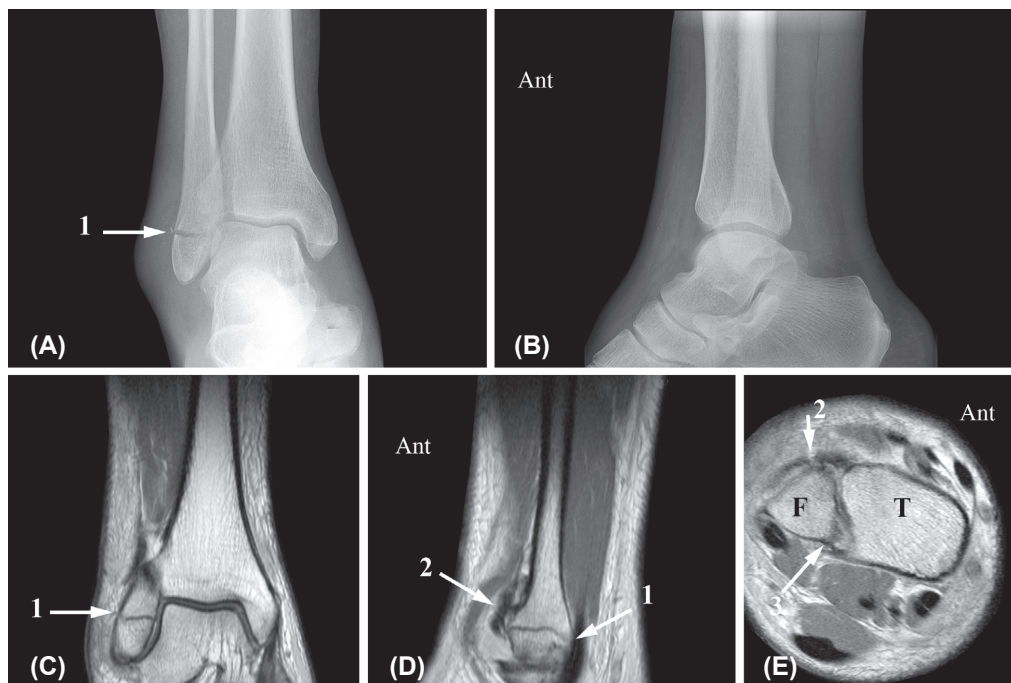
AP (A) and lateral (B) radiograph. A transverse fibular malleolar fracture (1) below the level of the tibio-talar joint line is visible. No fracture is visible at the medial or posterior malleolus. Measurements are normal. The fracture was classified as: Weber A, AO-Müller A1.3, Lauge-Hansen SA1. Coronal (C), sagittal (D) and axial (E) proton-density-weighted MR image. The transverse fibula fracture (1) is visible on the coronal and sagittal MR image. The lower border of the ruptured ATIFL (2) just lies across the fibula fracture as can be seen on the sagittal MR image (D). In the 45° oblique image (E) the ATIFL (2) is thickened and avulsed from the fibula. The PTIFL (3) is intact. Ant, anterior; T, tibia; F, fibula.
